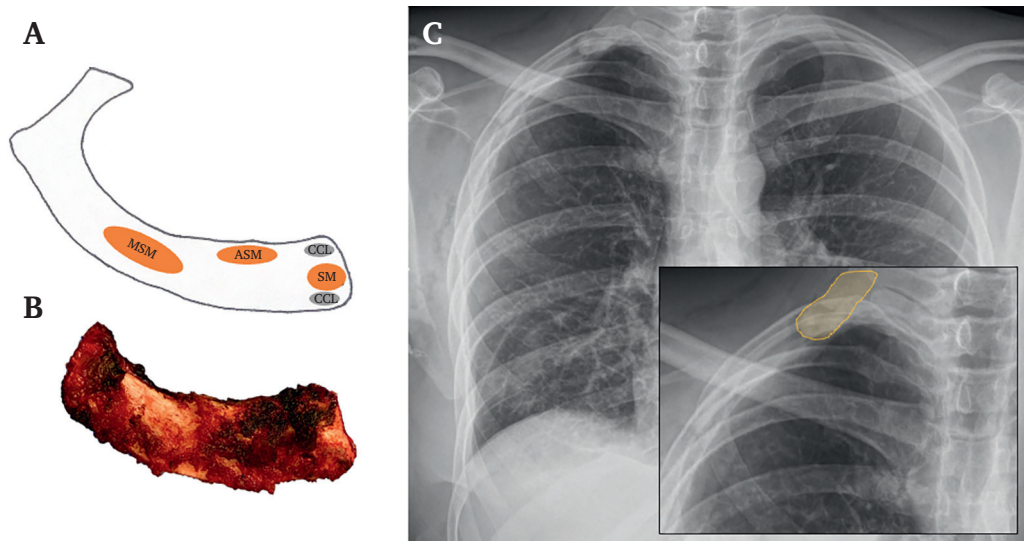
(A) Sketch. First rib with insertions of the anterior and middle scalene muscles (ASM, MSM), costoclavicular ligament (CCL), and subclavius muscle (SM). (B) Partial resection of first right rib: from the sternum to the posterior end of the rib insertion of the middle scalene muscle. (C) Post-operative radiographic view of partial resection of right first rib.
